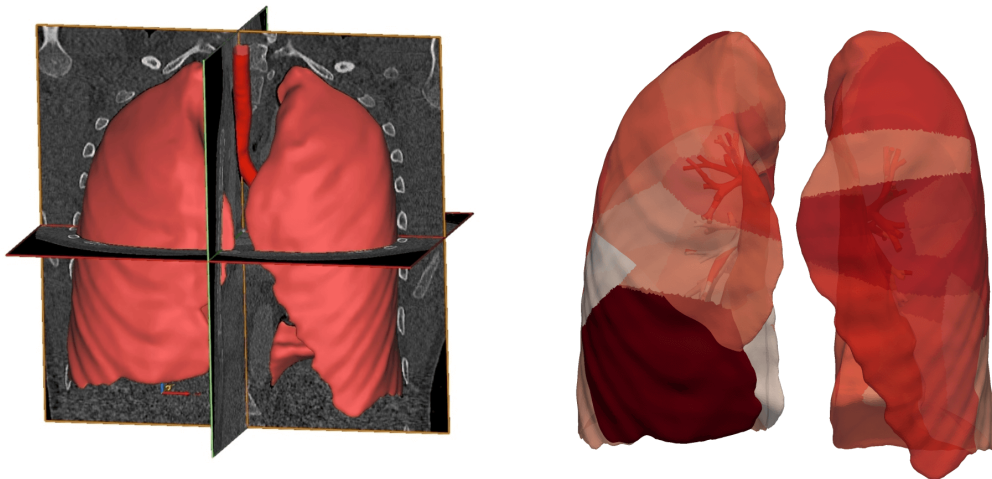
Visualisation of the CT scan A and the segmented contours of the lung lobes marked in red (left). The split lung tissue is pictured in the right.
